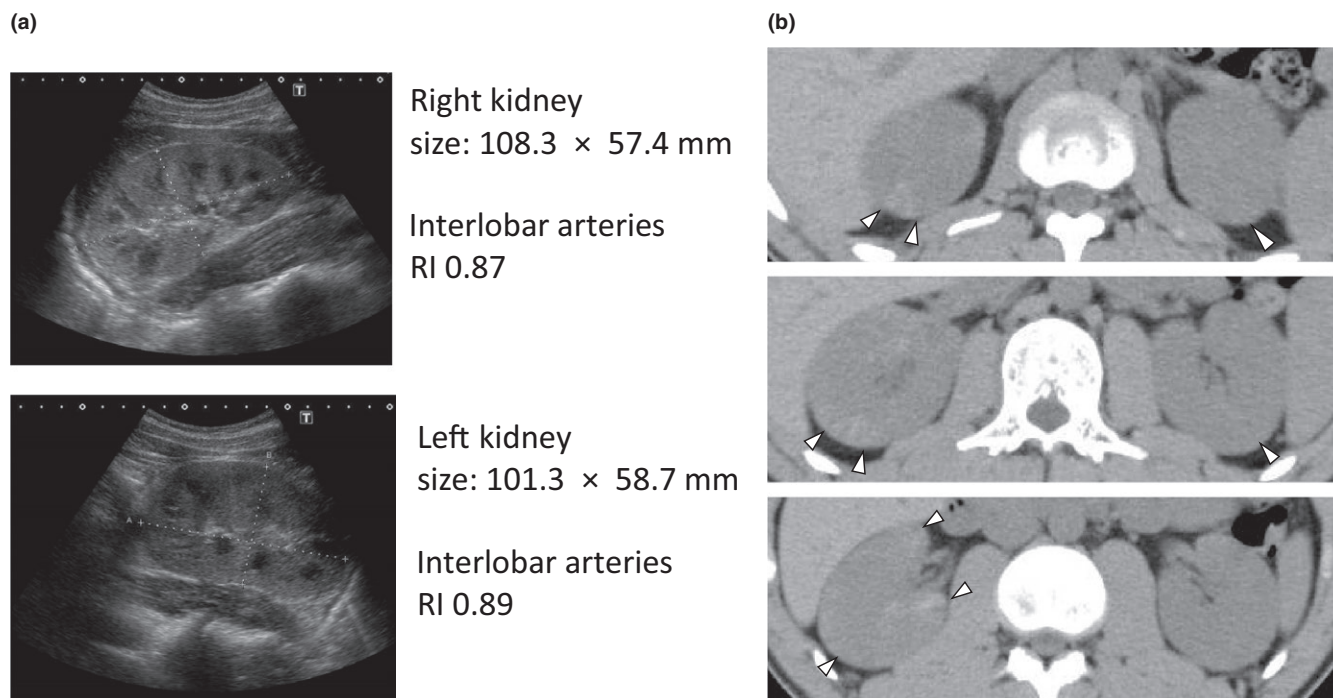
(A) Pulse Doppler ultrasound shows low perfusions at the level of the interlobar arteries on both kidneys. RI: resistance index. (B) Delayed computed tomography: Arrows show multiple wedge-shaped, patchy, high-density areas (a delay in excretion of contrast) on both kidneys on day 9
